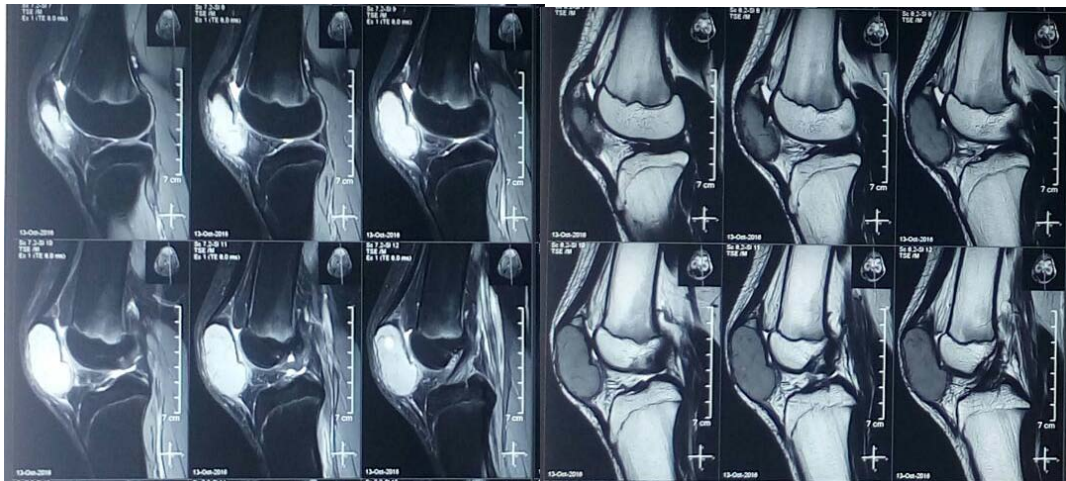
Sagittal T1 and T2 MRI show fluid-fluid level
